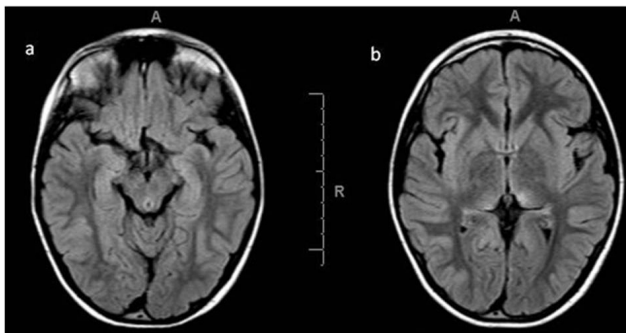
Control cranial MRI transverse FLAIR (Fluid attenuated IR) images (a,b) show almost complete resolution of the brain stem and brain lesions.
